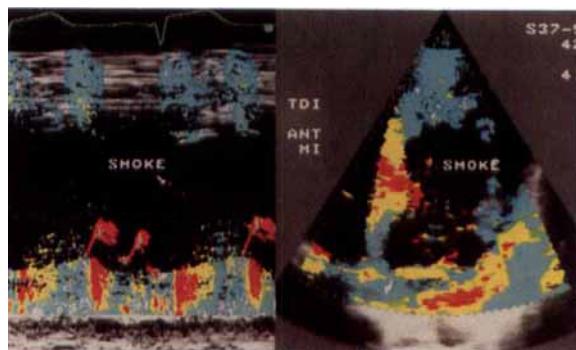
Apical four-chamber view with tissue Doppler imaging (TDI) enhanced imaging of spontaneous echo contrast. (Left) M-mode image through the left ventricle. (Right) Two-dimensional image on the right. (Velocity range, 3.55 cm/sec; nondirectional color velocity map.)
